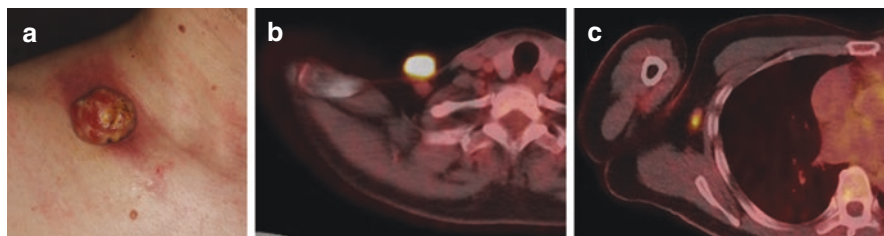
A typical case of melanoma in which the patient underwent ^{18}F -FDG PET-CT for staging ($>pT3$). A 48-year-old man developed amelanotic tumor with some pigmented areas on the edge at the right supraclavicular fossa (a). ^{18}F -FDG PET-CT detected a tumor measuring $25 \times 16 \times 20$ mm with SUV_{max} of 20.9 and SUV_{peak} of 15.3 (b). In addition, a lymph node with SUV_{max} of 8.27 was also detected in the right axilla (c), suggesting the presence of metastasis. Indeed, the lymph node had both S-100 and HMB45-positive melanoma cell infiltration (T4bN1M0 Stage)
